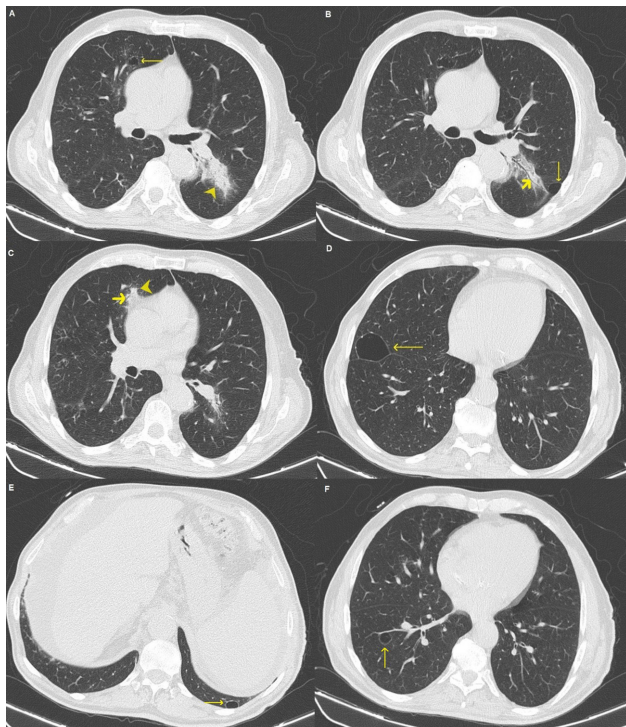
Axial chest CT images demonstrate bilateral parenchymal consolidations and several pulmonary cysts. (A, B) Dominant consolidation in the left lower lobe (arrowhead) with an associated air bronchogram (short arrow). (C) Smaller consolidation in the right middle lobe (arrowhead) with an air bronchogram (short arrow). (A–F) Several pulmonary cysts of variable size are present throughout both lungs (long arrows).
